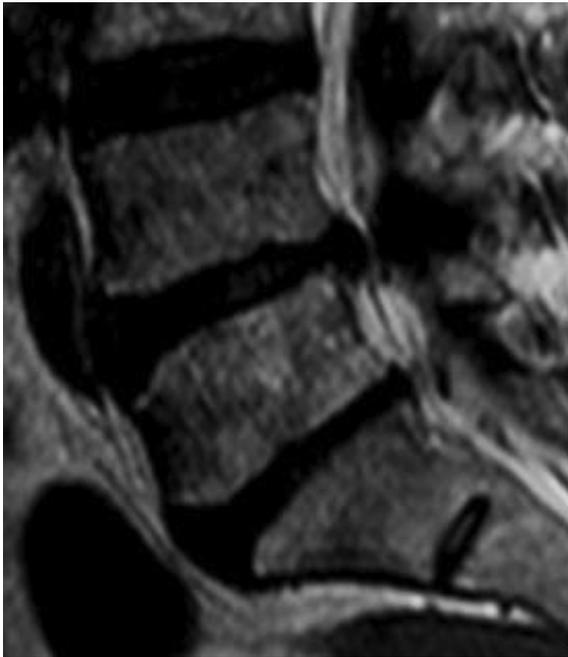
Saggital MRI lumbar view.
